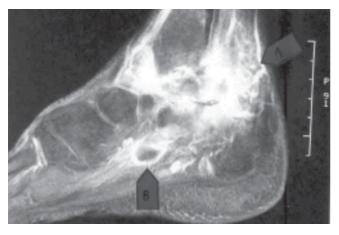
Magnetic resonance imaging (sagittal view) of left ankle. (A) Increased signal intensity (T2W) in the distal tibia, talus and calcaneum suggestive of osteomyelitis, with marked soft tissue swelling around the joint. (B) Ovoid lesion with rim enhancement post-gadolinium; representing an abscess collection plantar to the tarsal bones in close relation to the talocalcaneal joint.
